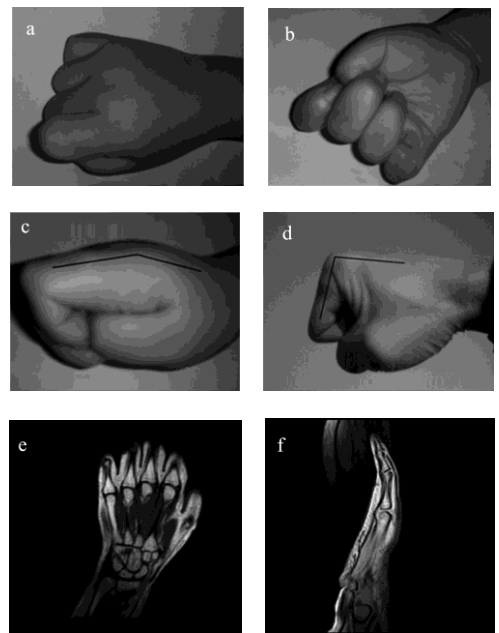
Rigidity and inability of bending the metacarpophalangeal joints, unable to make a fist. It is noticeable that the flatness of the opisthenar and the special arrangement of fingers in the maximal flexure position (graph a & b). Patient's maximal metacarpophalangeal joint angle is ~30° (graph c), in comparison with the normal angle of ~90° (graph d). The hand MRI showed good joint spaces without detectable abnormalities on bone, cartilages, muscles or tendons (graph e & f).
